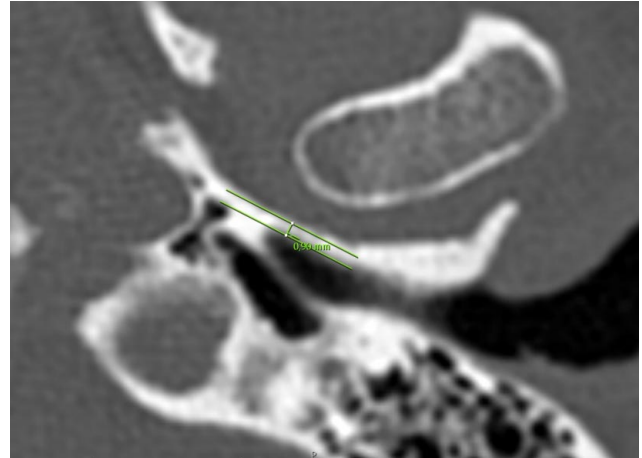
Temporal CT image of a 71-year-old man (Left NTT).
